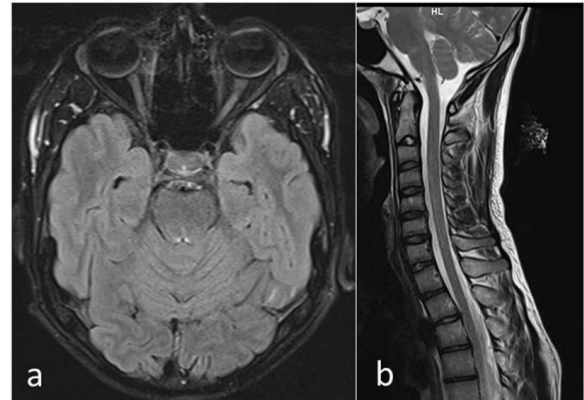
Axial FLAIR image (a) at the orbit level shows normal signal of both optic nerves. Sagittal T2WI (b) of cervical spine shows normal cord signal.
